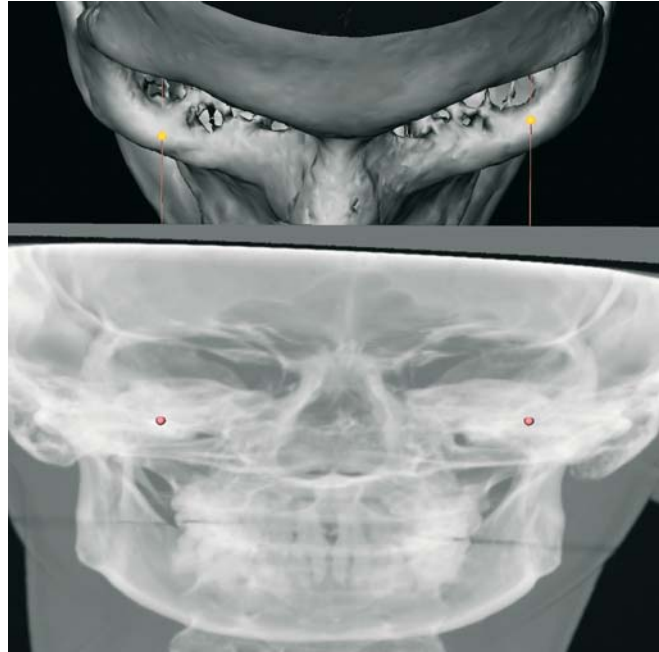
Orbita_r and Orbita_l, Virtual frontal cephalogram linked to the 3-D hard tissue surface representation (3-D CT, patient K.C.) allows verification of the position of the Orbita_r and Orbita_l landmarks
